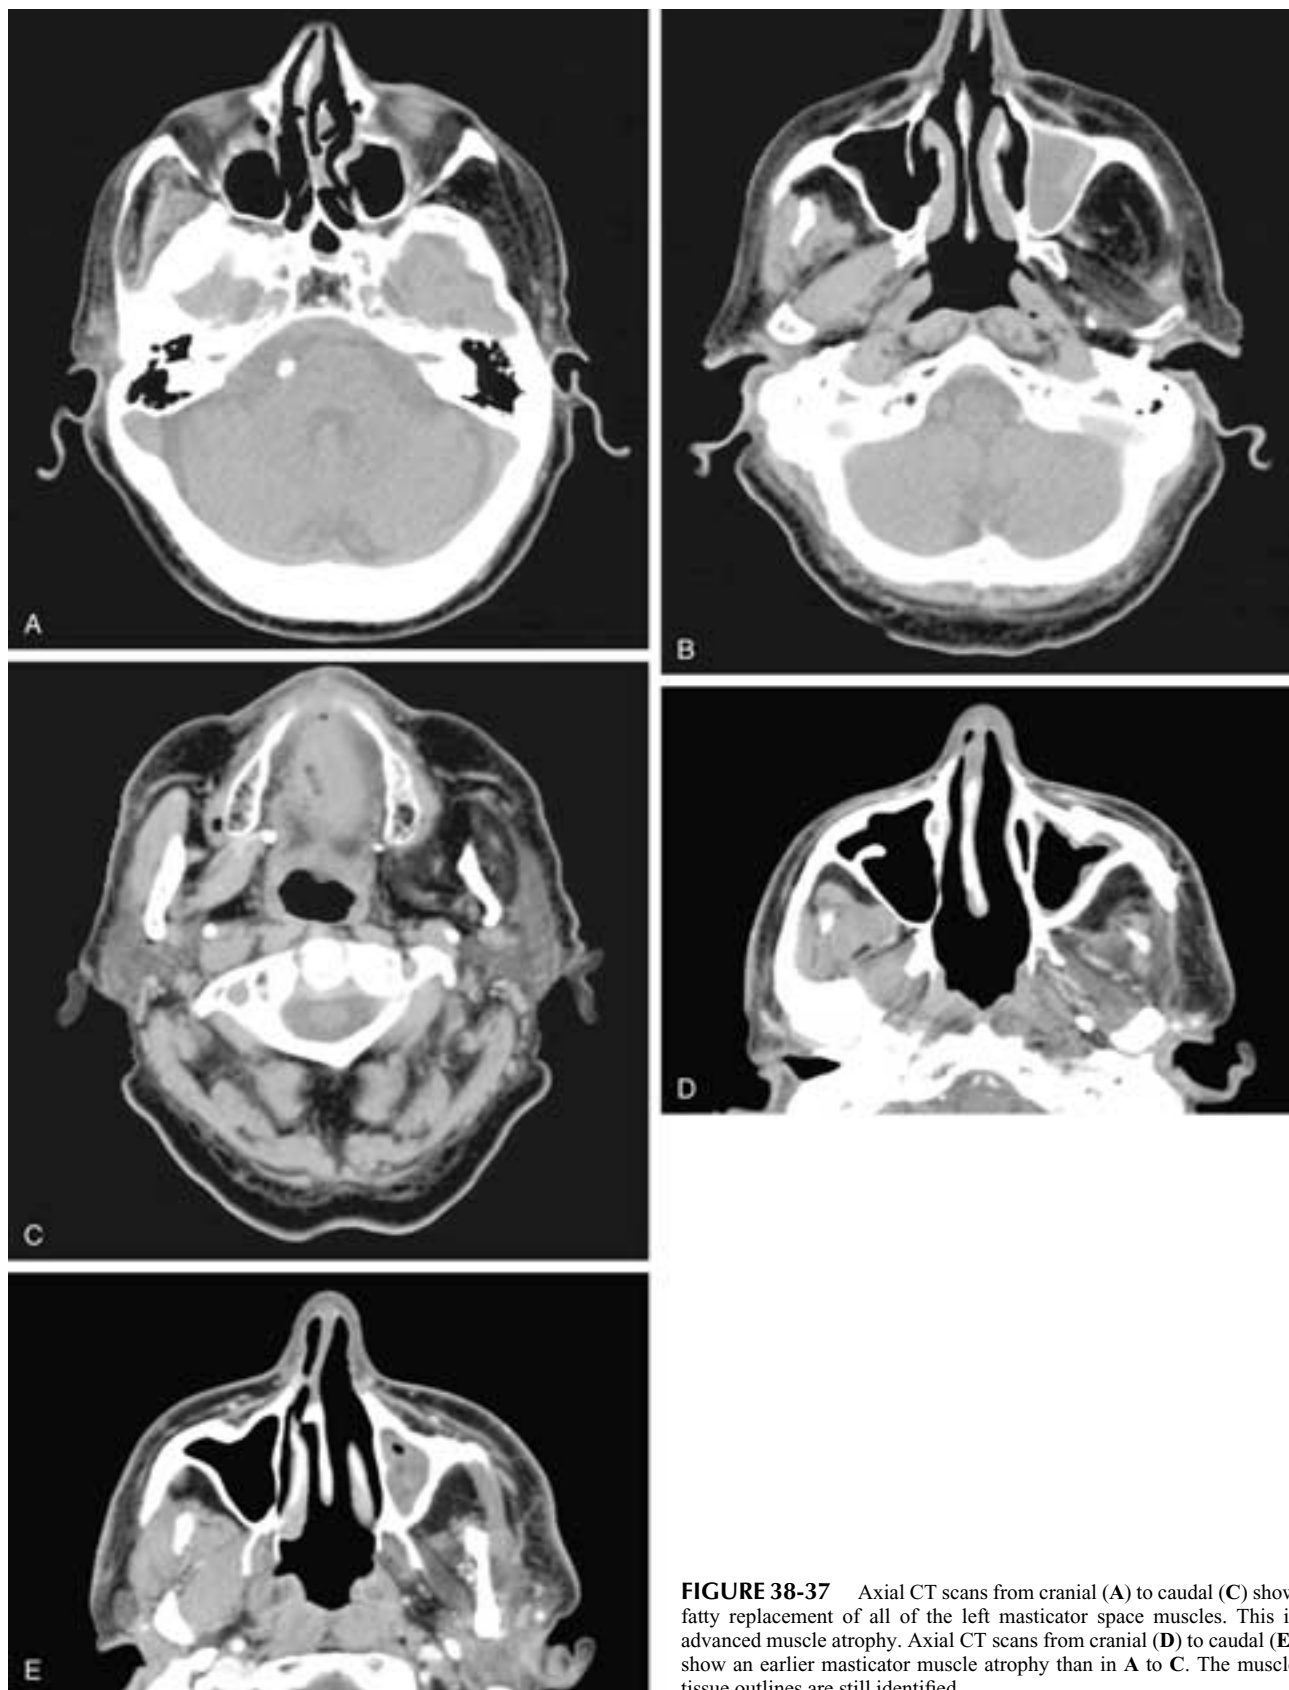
Axial CT scans from cranial (A) to caudal (C) show fatty replacement of all of the left masticator space muscles. This is advanced muscle atrophy. Axial CT scans from cranial (D) to caudal (E) show an earlier masticator muscle atrophy than in A to C. The muscle tissue outlines are still identified.
